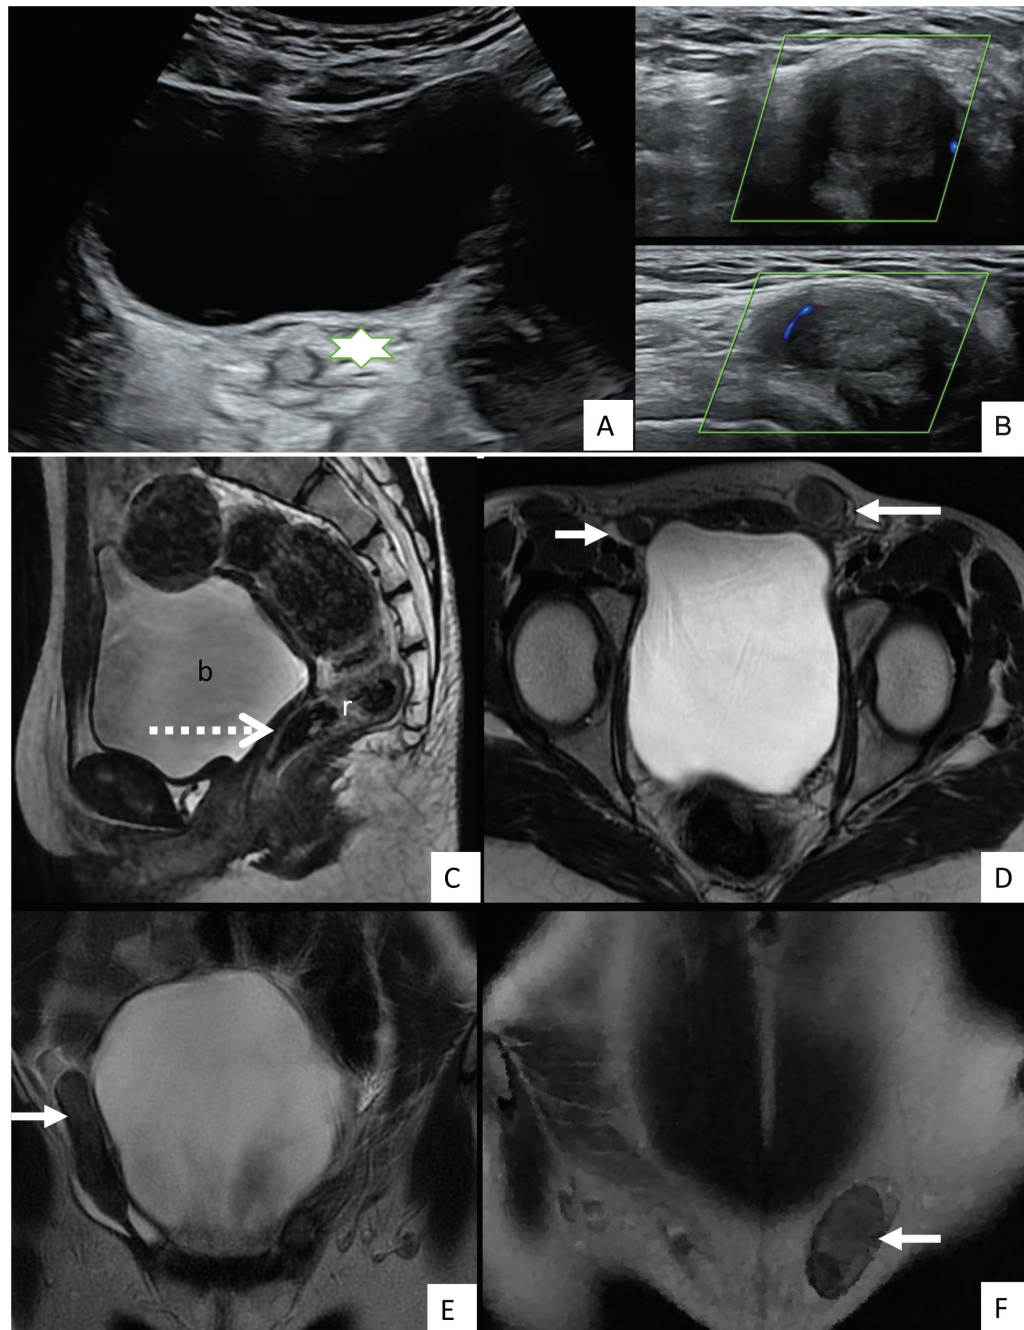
Transabdominal ultrasound of the pelvis in the younger sister aged 17 years reveals (A) absence of uterus in the retrovesical location (marked by star) and presence of testes (B) in the right and left inguinal canals, respectively. Sagittal T2-weighted magnetic resonance imaging (MRI) image (C) reveals absence of uterus (dotted arrow) between the urinary bladder (b) and rectum (r). Axial T2-weighted MRI image (D) shows presence of ectopic testes in the bilateral inguinal canals anterior to the urinary bladder (arrows). Coronal T2-weighted images (E) and (F) confirm the presence of testis in the bilateral inguinal regions (arrows).
